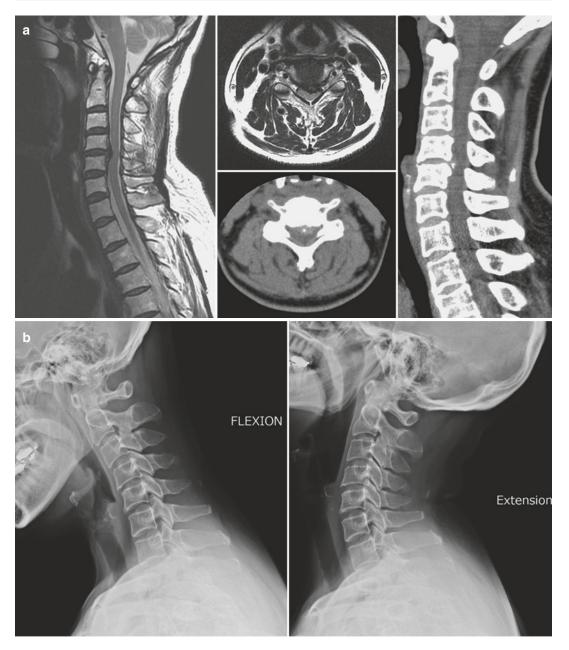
(a) Preoperative T2-weighted magnetic resonances images (MRI) and computed tomography (CT) scans demonstrated a large C4–C5 disc herniation with slight calcification causing compression to the thecal sac that required a cervical discectomy. (b) The lateral flexion and extension radiographs demonstrated good
